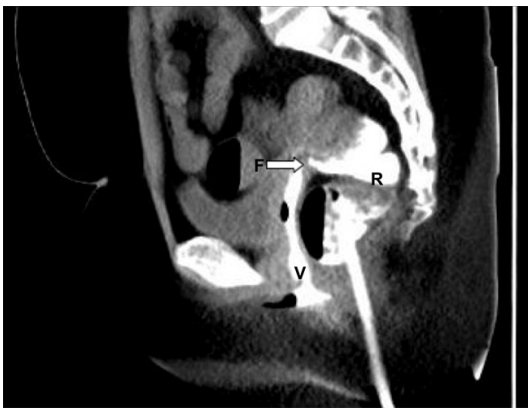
A 58 years old female patient with endometrial cancer received laparoscopic hysterectomy, oophorectomy and pelvic lymphadenectomy. However, vaginal exhaust and defecation occurred 2 weeks after surgery. The patient underwent laparoscopic repair of rectovaginal fistula 2 months after surgery. CT imaging in the coronal plane of rectal perfusion before surgery showed contrast agent flowing into vaginal through the rectovaginal fistula (arrow). V, vaginal; R, rectum; F, fistula.
